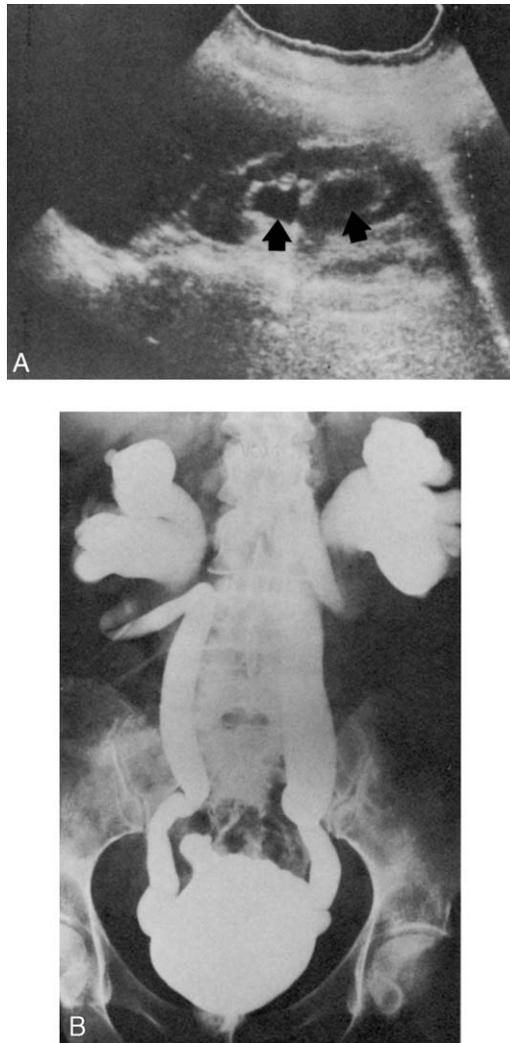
Vesicoureteral reflux with ultrasound scan false-positive for obstructive hydronephrosis. (A) Longitudinal view of right kidney demonstrates dilated collecting system (*arrows*). (B) Cystogram reveals massive bilateral reflux as the cause of the collecting system dilatation. (From Amis ES, Hartman DS. *Renal ultrasonography 1984: a practical overview*. *Radiol Clin N Am* 1984;22:323; with permission.)
